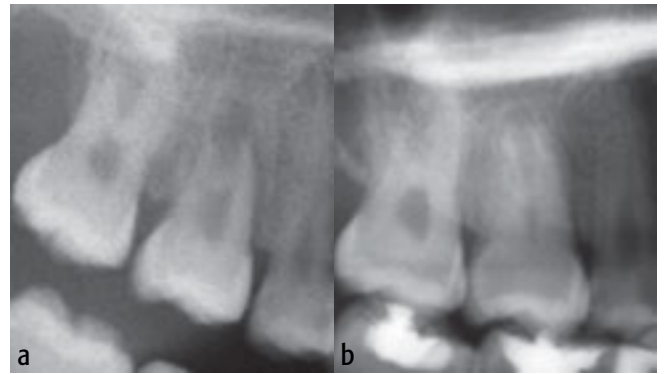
Postoperative radiograph (4a) and radiograph after one year (4b), with a narrowed pulp chamber and root growth of advanced tooth 18 to point 16
